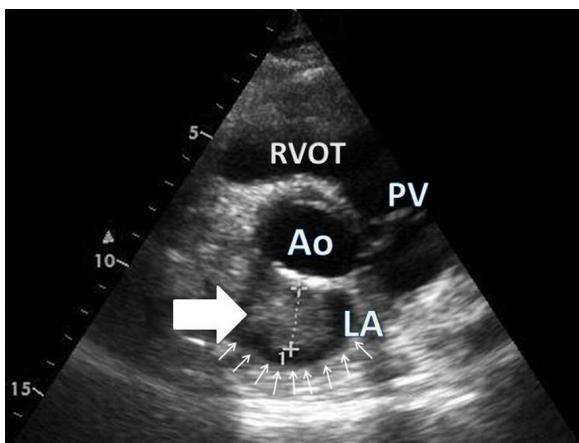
Parasternal short axis transthoracic echocardiography image at the level of the aortic valve. The left atrium is delineated by the small white arrows, while the big slide arrow points an echogenic mass (vegetation) with a maximum diameter (line with crosses) of 2 cm, almost filling the left atrium. Vegetation is originated from the mitral valve, not displayed in this cross section. Ao: aortic valve, RVOT: right ventricular outflow tract, LA: left atrium, PV: pulmonic valve.
